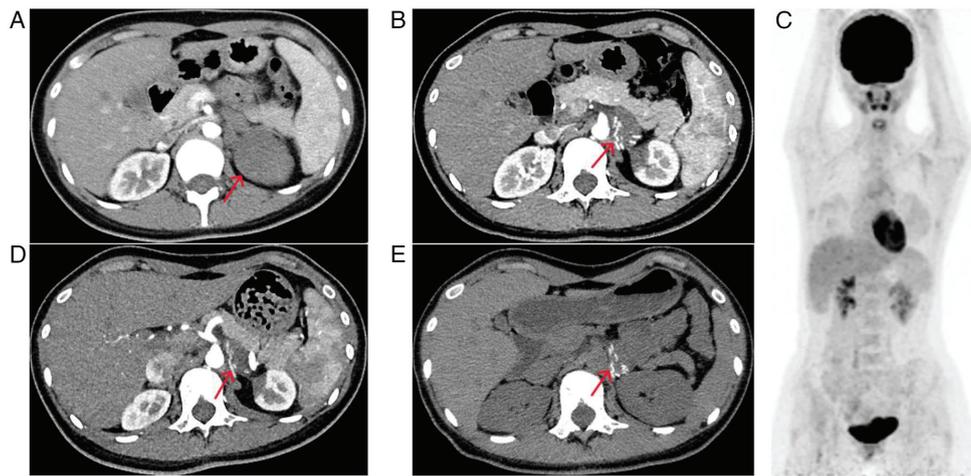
Imaging at admission and follow-up. (A) Arterial phase imaging revealed a solid mass in the left adrenal gland, measuring $\sim 5.7 \times 4.1$ cm in maximum diameter. (B) Imaging at 3 months post-surgery indicated a solid mass in the region of the initial surgery, now measuring $\sim 3.5 \times 2.0$ cm, suggesting the possibility of recurrence. (C) positron emission tomography-computed tomography scans at 4 months post-surgery showed no evidence of metastasis throughout the body. (D) Postoperative imaging at 7 months demonstrated a reduction in mass size compared with earlier findings, with a maximum diameter of $\sim 2.6 \times 2.0$ cm. (E) At the 12-month follow-up, the mass exhibited further shrinkage, with a maximum diameter of $\sim 2.6 \times 1.8$ cm. Red arrows indicate the mass.
